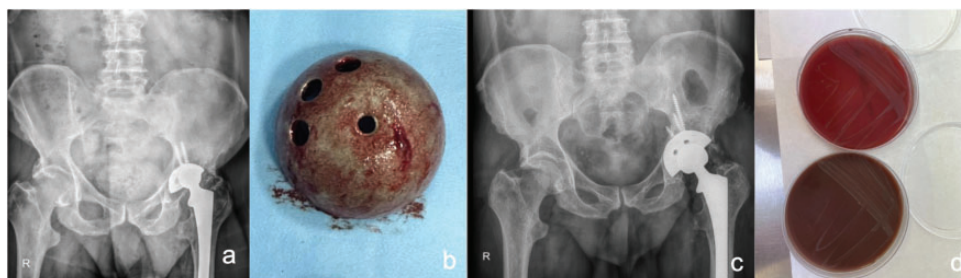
(a) Preoperative X-ray of Case 4 showing subtle signs of implant loosening in the left hip after total hip arthroplasty, prompting one-stage revision surgery. (b) Intraoperative X-ray of Case 4 demonstrating the previous acetabular cup with complete bone resolution around it during revision surgery. (c) Final follow-up X-ray of Case 4 at 12 months showing a well-fixed implant with no signs of infection recurrence and (d) bacterial growth on blood agar (top) and chocolate agar (bottom), confirming a positive culture for *Brucella melitensis*. The colonies appeared small, nonhemolytic, translucent, and smooth after prolonged incubation (on 16th day).
